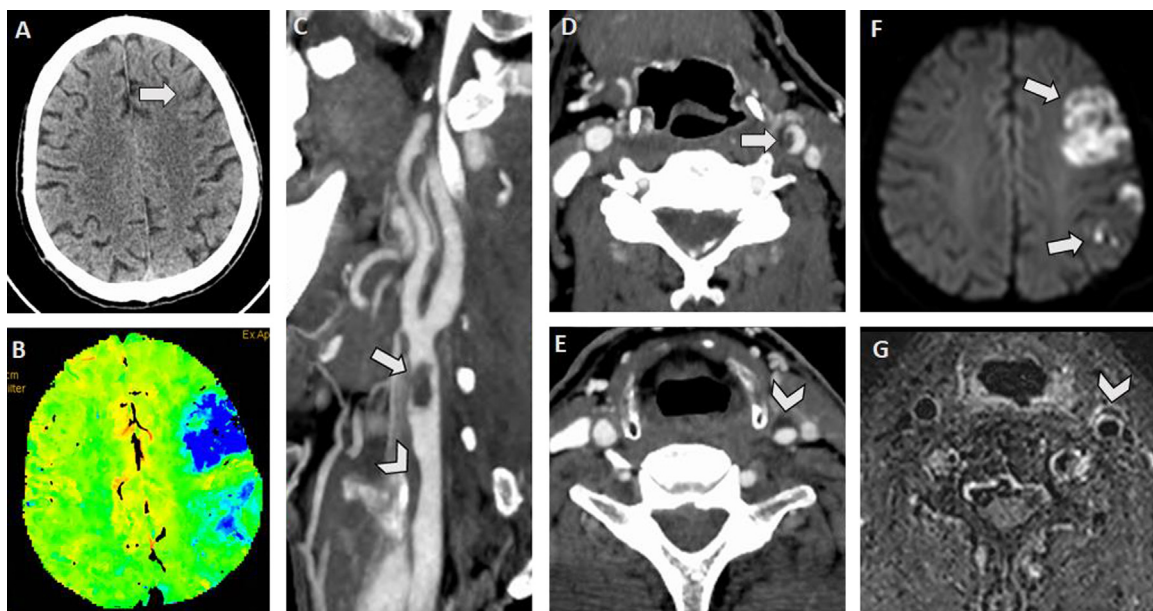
66-year-old patient with COVID-19 lung infection and acute stroke. A. Axial head CT performed 9 hours after symptoms onset barely depicts left frontal cortical hypoattenuation (arrow). B. Perfusion CT reveals larger area of hypoperfusion (in blue). C-E. CT angiography demonstrates large floating intraluminal thrombus in the distal left common carotid artery (arrows on C and D) adherent to a non-stenosing hypoattenuated plaque (arrowheads on C and E). F. Axial Diffusion-Weighted image shows multiple ischemic lesions in the left hemisphere. G. MRI wall imaging with gadolinium-enhanced axial black-blood SPACE T1-weighted image with fat saturation reveals peripheral enhancement of the plaque only, without circumferential thickening of the common carotid artery.
